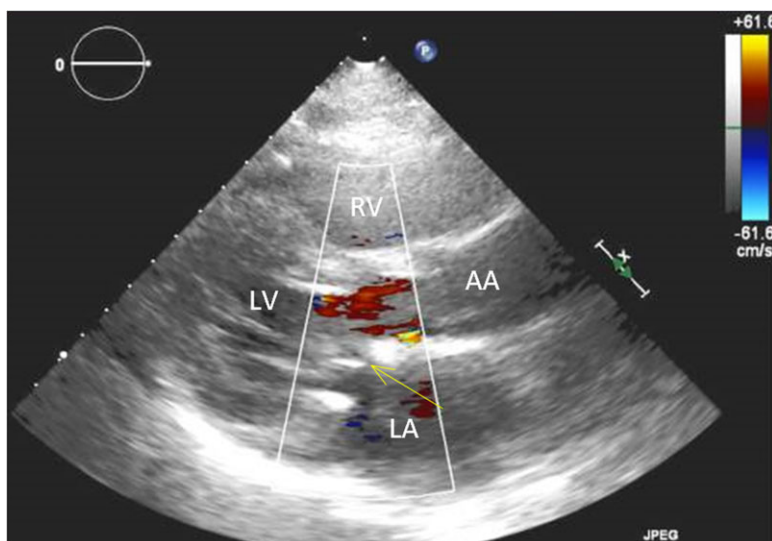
Longitudinal long-axis transthoracic echography after an uneventful vegetation excision, partial leaflet resection, and reconstruction by pericardial patch and ring annuloplasty (the latter is indicated by the arrow). Traces of colour Doppler flow in the left atrium indicates severe mitral regurgitation resolution after surgery. Anatomical landmarks: AA, ascending aorta; LA, left atrium; LV, left ventricle; RV, right ventricle.
